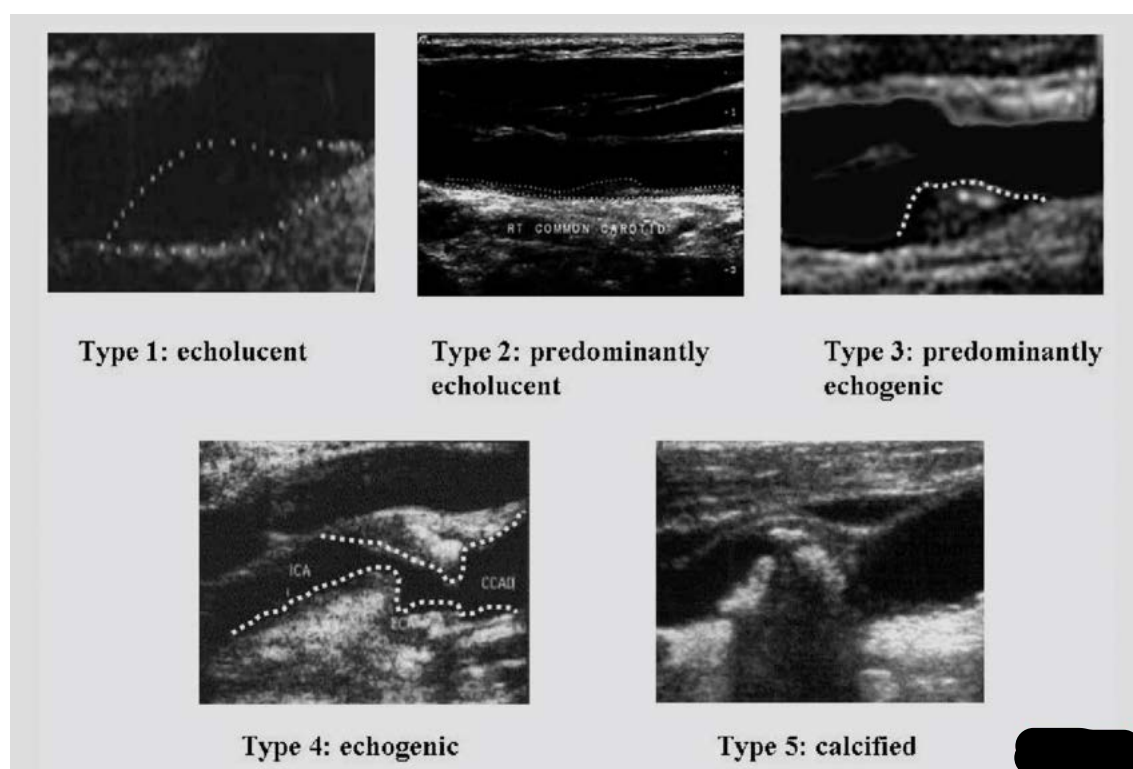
Plaque classification by ultrasound. Figure taken from Sirico et al (42).
